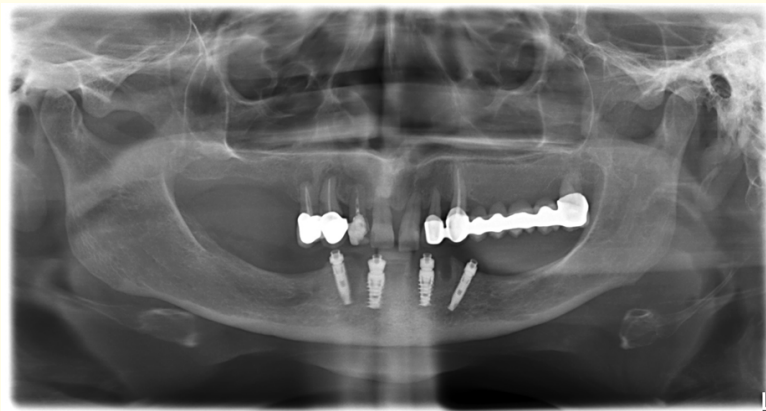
Pre-op panoramic X-ray.
